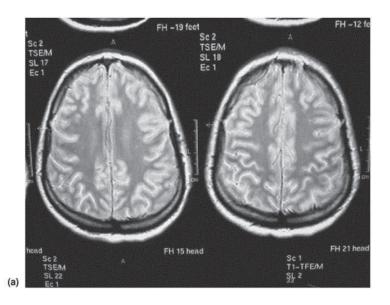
MRI scanned image. (a) Without data compression (FONG *et al* 2011)
